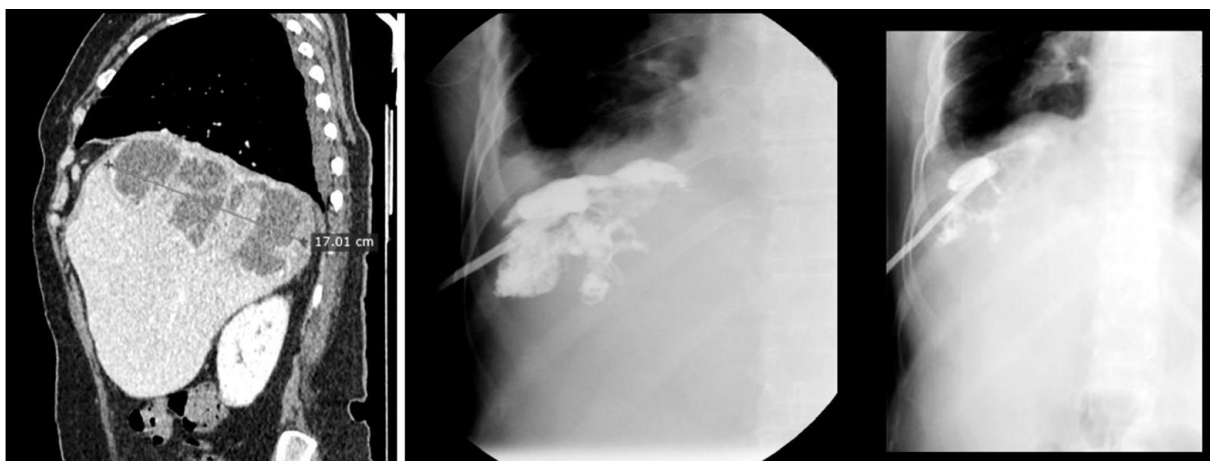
Drainage of a multiloculate abscess – follow-up: CT before drainage – large collection in the right lobe; contrast-medium injection into the cavity 5 days and 12 days after percutaneous placement of catheter showing decreasing of the cavity and of the number of septae
